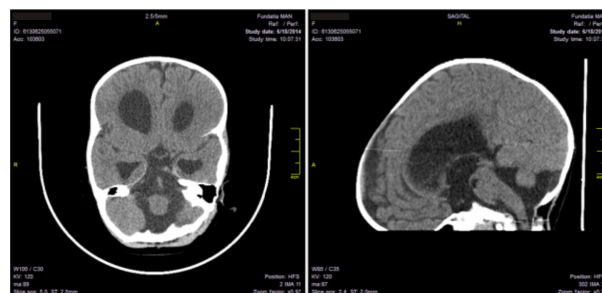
Dandy-Walker malformation. CT scan: hydrocephaly, vermis agenesis, mega cisterna magna.
